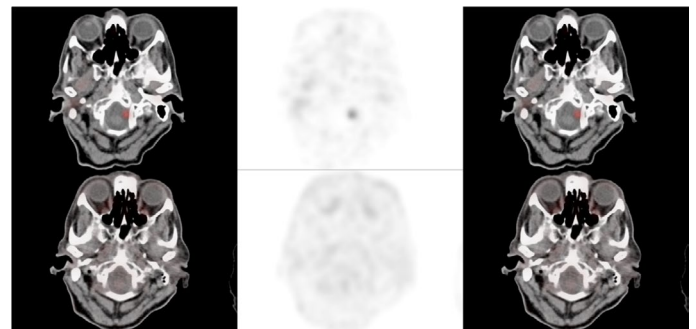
Ga-68 DOTATATE CT, PET and fusion PET/CT respectively images of the patients in axial projection demonstrates the increased activity in in left lateral brain stem region (A: upper line) however F-18 FDG PET/CT images do not show FDG uptake at the lesion site (B)
